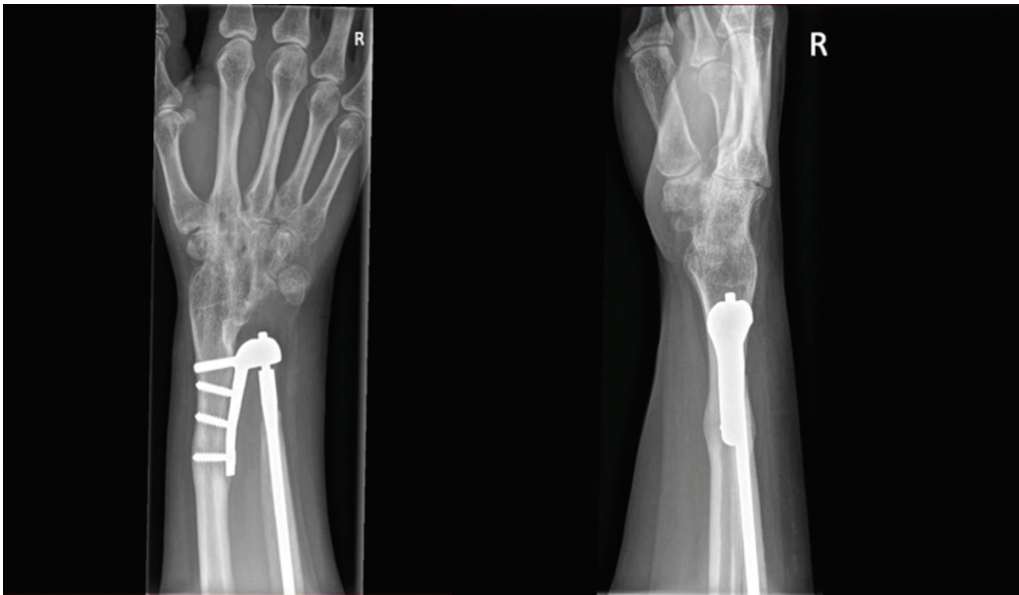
Anteroposterior and lateral X-rays of Case 2, 13 months after the placement of the Aptis implant.
